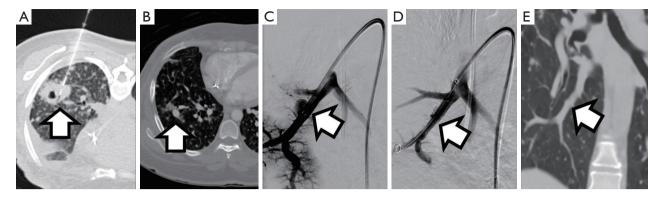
A 28-year-old woman with a cavitary right lower lobe lung lesion that was biopsied at an outside hospital (A, arrow). Approximately 3 months after the biopsy, the patient presented with progressively worsening shortness of breath and chest imaging confirmed pneumonia. An incidental finding of a pseudoaneurysm was noted in the right lower lobe (B, arrow), which was likely a complication of the prior biopsy. After completion of antibiotics and resolution of pneumonia, the patient presented for endovascular treatment given the risk for life-threatening bleeding if the pseudoaneurysm were to rupture. A selective angiogram in the right lower lobe pulmonary artery demonstrated the pseudoaneurysm arose from the basilar segmental branch and contained a large neck (C, arrow). A covered stent was placed across the pseudoaneurysm to provide complete occlusion of the pseudoaneurysm and persistent patency of the stent (E, arrow). CT, computed tomography.
